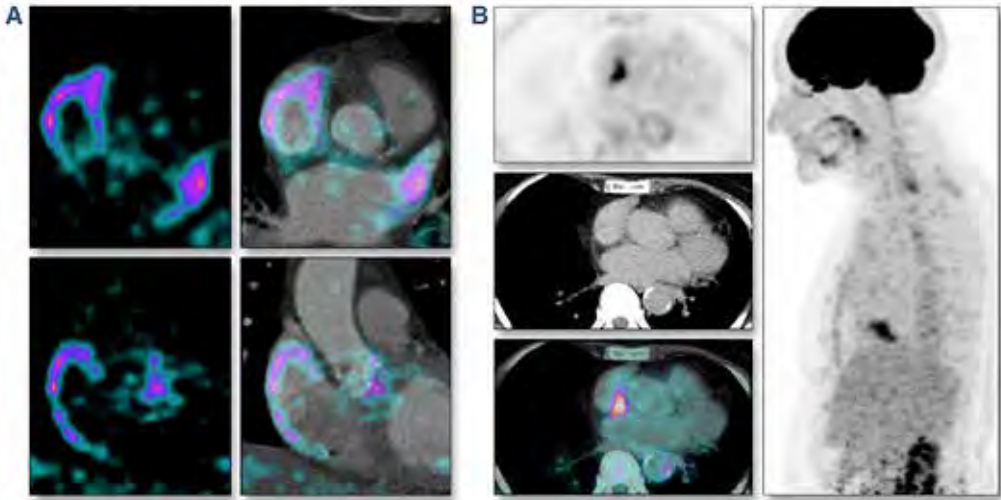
Atrial variants. In atrial fibrillation, the uncoordinated contraction of the atrial myocardium leads to high energy consumption and a consequent up-regulation of glucose metabolism leading to increased uptake of ^{18}F -FDG, even though the ventricular myocardial glucose metabolism may be completely suppressed. Such accumulation of ^{18}F -FDG in the atrial myocardium may lie adjacent to PHV and may be hard to differentiate from infectious foci (A). Lipomatous hypertrophy of the interatrial septum is associated with moderately to intensely increased uptake of ^{18}F -FDG, presented here in a patient without a PHV (B). Especially in patients with PHV in the aortic position, lipomatous hypertrophy of the interatrial septum may be located adjacent to the valve. Typical barbell-shape and fatty density without stranding on CT images are arguments against infection.
